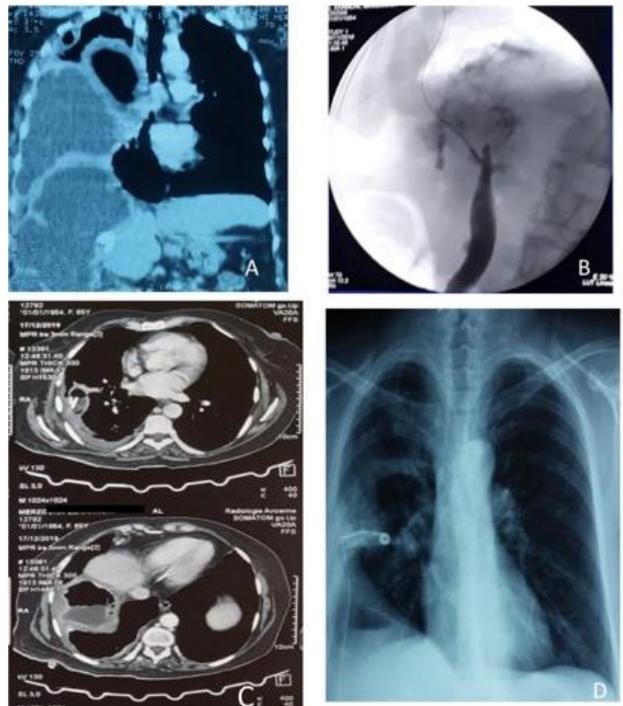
Patient # 4 X-Ray and Endoscopic Iconography: A. Abdominal chest CT showing hydatid liver cyst communicating with pleural collection. B. ERCP showing common bile duct obstruction. C. Post sphincterotomy and post pleural drainage abdominal chest CT showing a pleural collection regression. D. Chest x-ray check made one month later and after pleural drainage showing significant radiological improvement.
